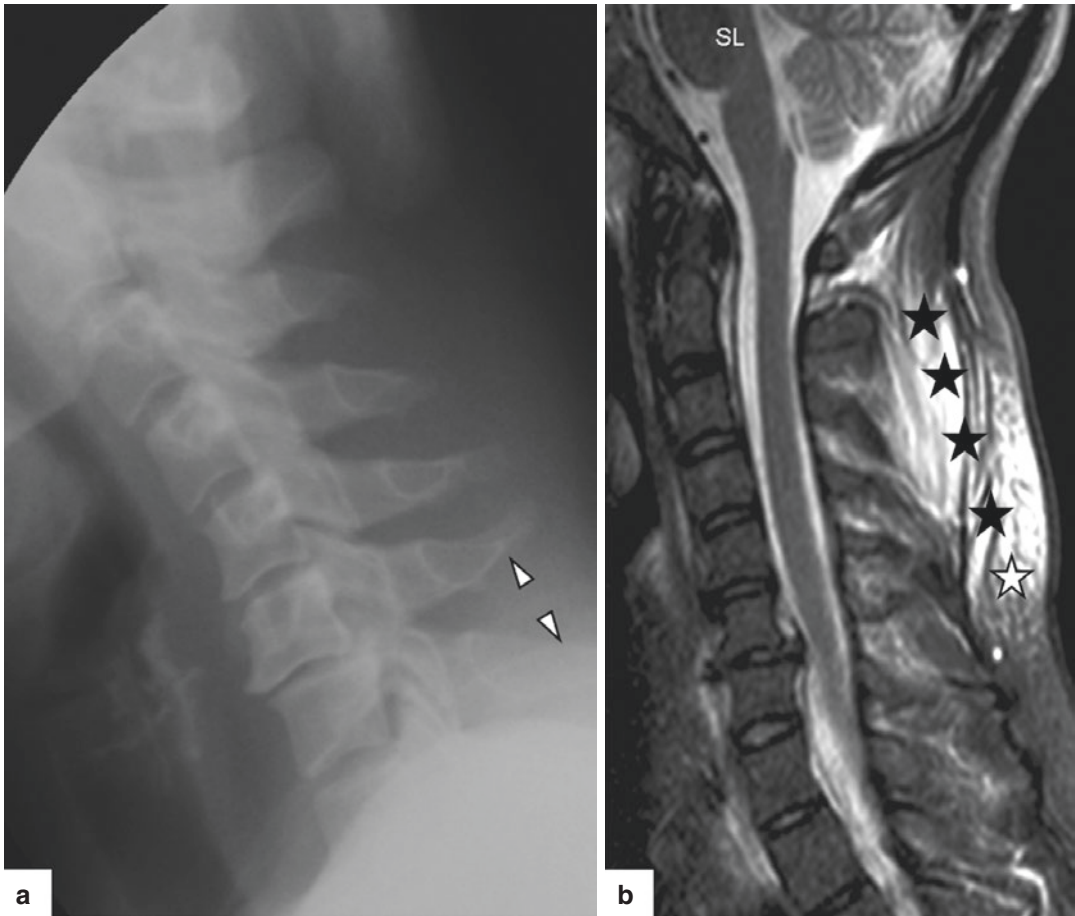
Hyperflexion injury in a 58-year-old male. Lateral radiograph (a) shows increased interlaminar and interspinous distances (arrowheads). Sagittal T2-weighted MR
